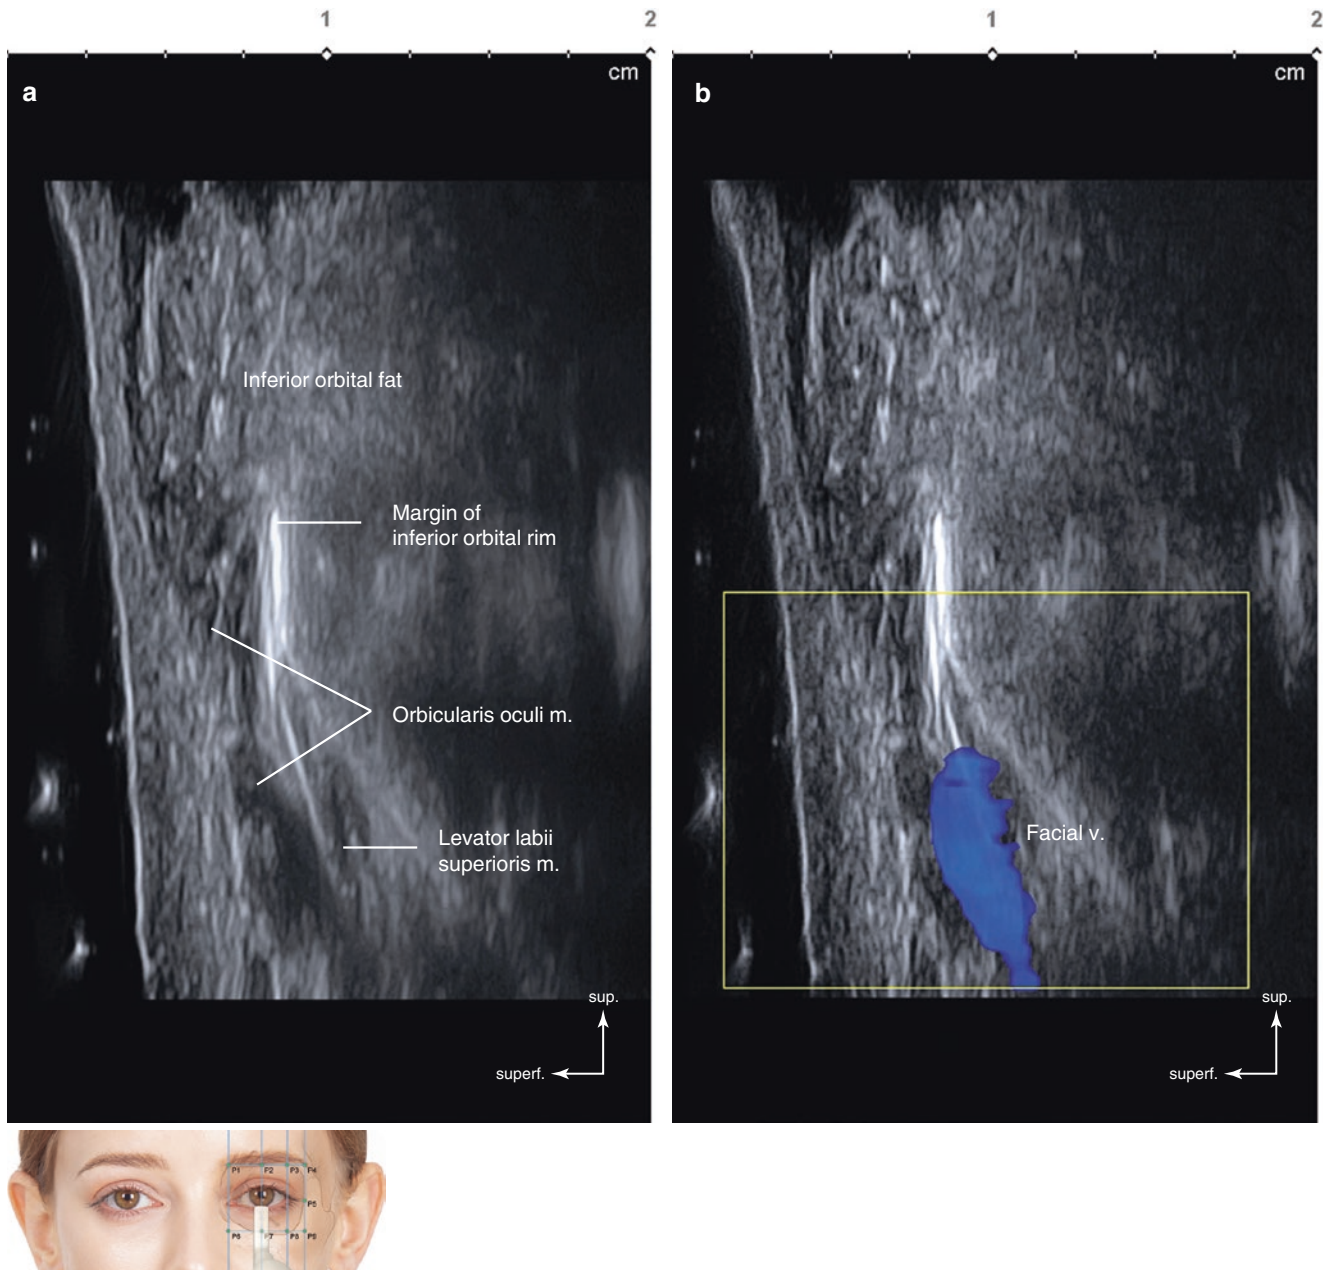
Ultrasonography on the intersection point of TL3 and PL2 (P7). (a) B mode (sagittal view, 15 MHz by linear transducer) and (b) Doppler mode (sagittal view, 15 MHz by linear transducer). (Published with kind permission of © Hee-Jin Kim 2020. All Rights Reserved)
